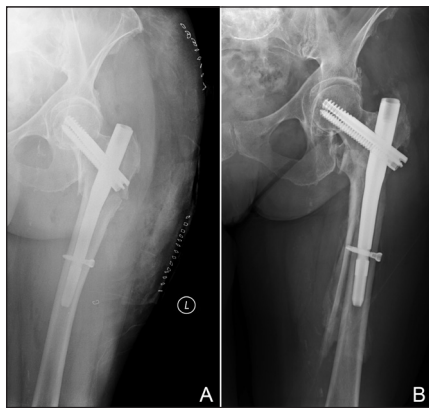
Anteroposterior radiograph showing a short cephalomedullary nail in a 75-year-old woman after pertrochanteric femur fracture (A). Anteroposterior radiograph showing periprosthetic fracture 32 days after the index procedure (B). The patient underwent revision to a long cephalomedullary nail.
